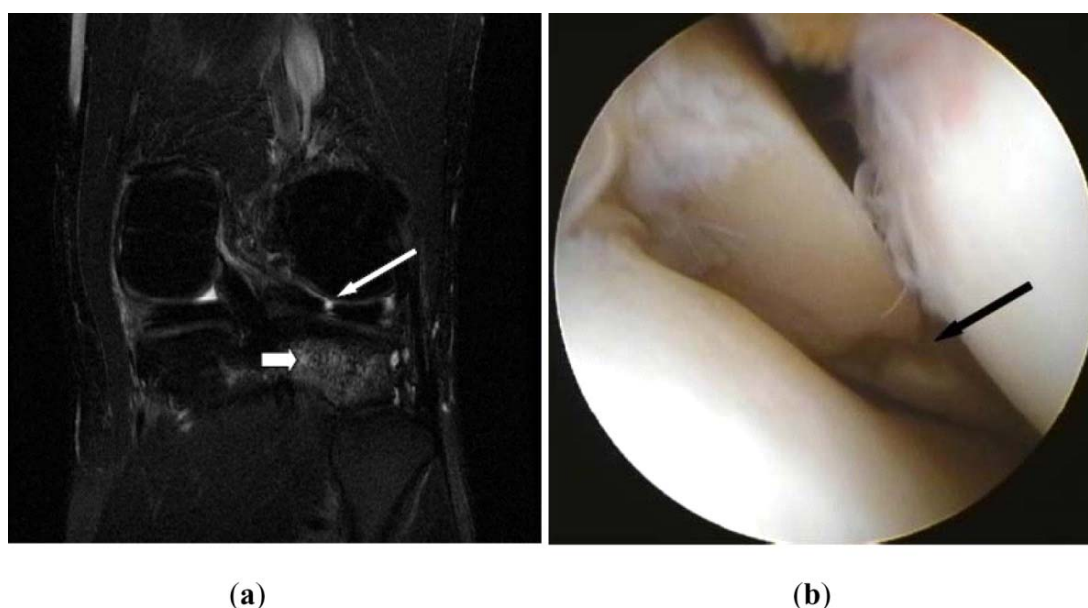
A 21-years-old male. On coronal T2-weighted image with fat suppression (a) revealed radial tear at posterior of lateral meniscus (indicated by a thin white arrow). Knee arthroscopy (b) demonstrated a meniscal tear (indicated by a black arrow) at the same region. Bone bruise (thick white arrow) at posterior aspect of proximal tibia on coronal T2-weighted image with fat suppression (a) was shown.
